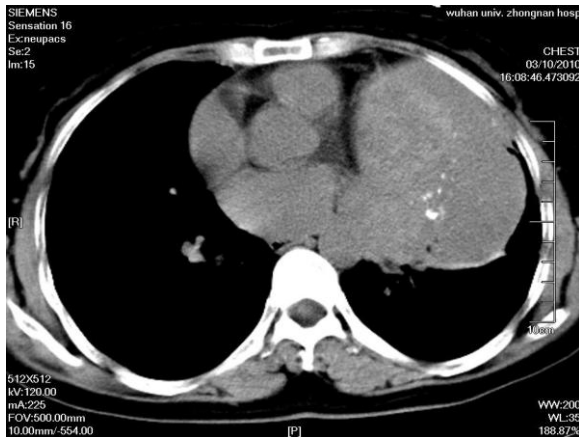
Non-contrast enhanced CT scan demonstrates a lobulated homogeneous mass in the lower lobe of the left lung. Lesion is abutting the chest wall and demonstrates few calcifications.
